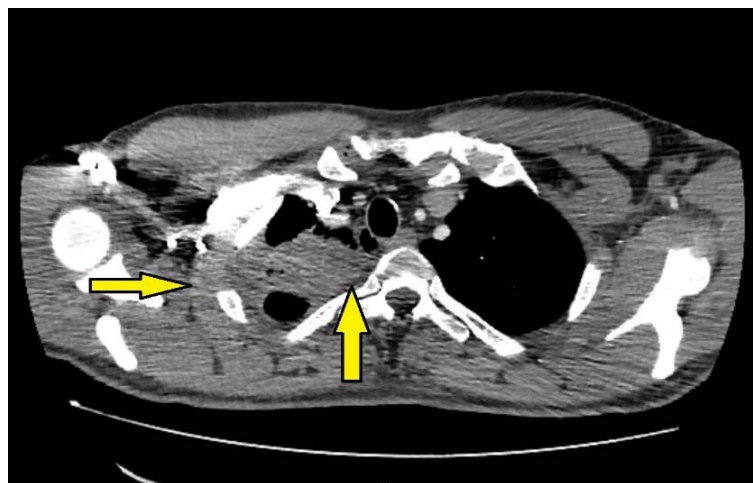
Chest multi detector computed tomography (axial section) demonstrating areas of demarcation between pulmonary parenchymal changes and the adjacent pleura (arrows).
